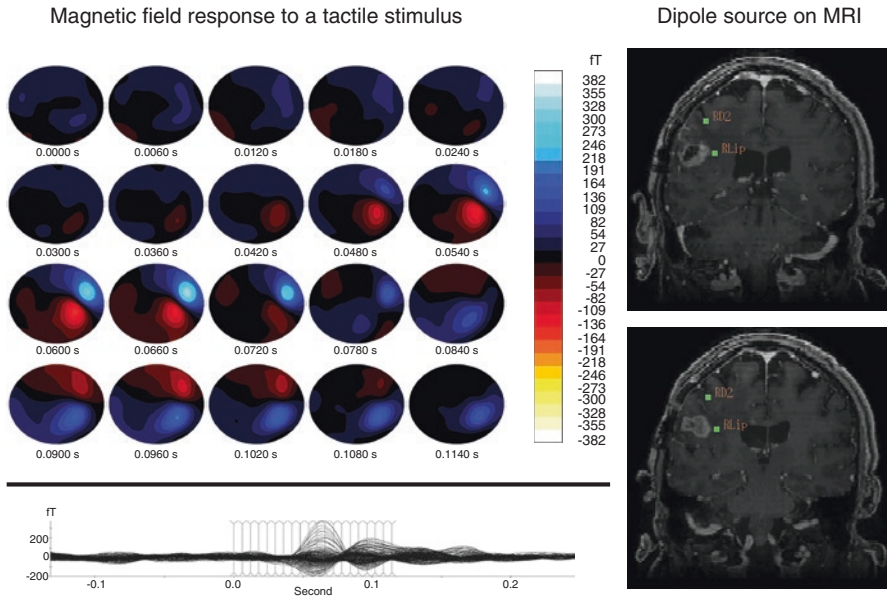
MEG recordings of somatosensory stimuli. Sample MEG of somatosensory stimuli to the right lip (RLip) and right index finger (RD2). Multiple stimulus trials are performed for each site and cortical magnetic fields are recorded. The trials are averaged and a single dipole is reconstructed for each site using the least-square fit method. On the left are depicted the results in 0.006 s intervals, with the magnetic dipoles represented as *red-orange* (negative fT) to *blue-white* (positive fT). On the right, the resulting dipoles are then displayed on a coregistered, T1-weighted post-gadolinium coronal MR slice. On the bottom of the figure is the overall time course of magnetic field with all trials superimposed
